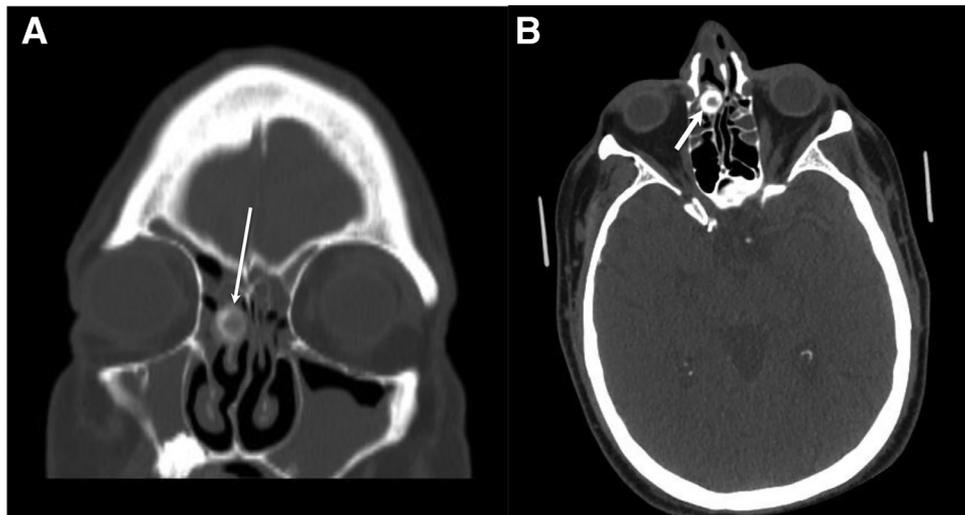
Juvenile ossifying fibroma. On coronal computed tomography (A), the ossifying fibroma is seen abutting the middle turbinate with characteristic ovoid shape (thin arrow). On axial view (B), the sclerotic border is highlighted (thick arrow). Images courtesy of Ricardo Carrau, MD.
